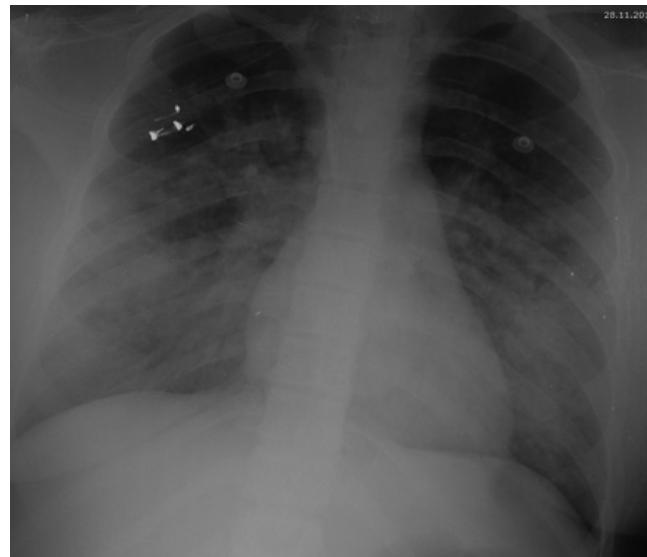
Chest X-ray performed four hours after hospitalization which is compatible with acute respiratory distress syndrome
